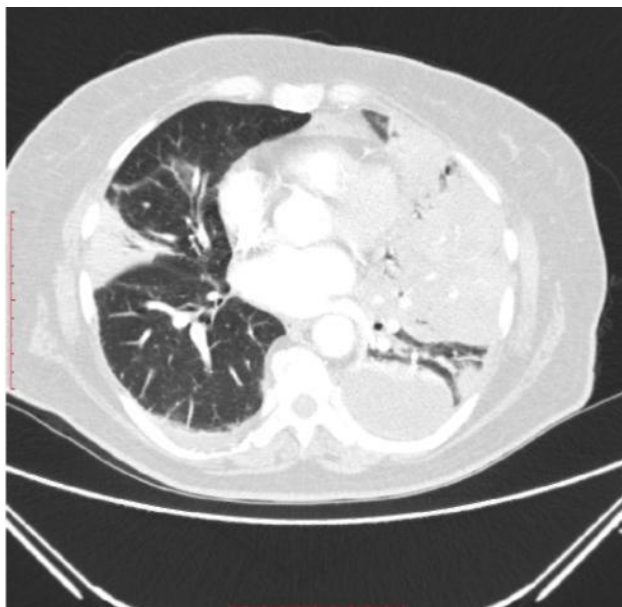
Chest computed tomography (8/02/2013). An effusion in the left pleural cavity, partially in adhesions. Massive left lung inflammatory consolidation. Inflammatory changes in seg. 4 of the right lung, mainly at the chest wall, a small amount of effusion in right pleural cavity.
